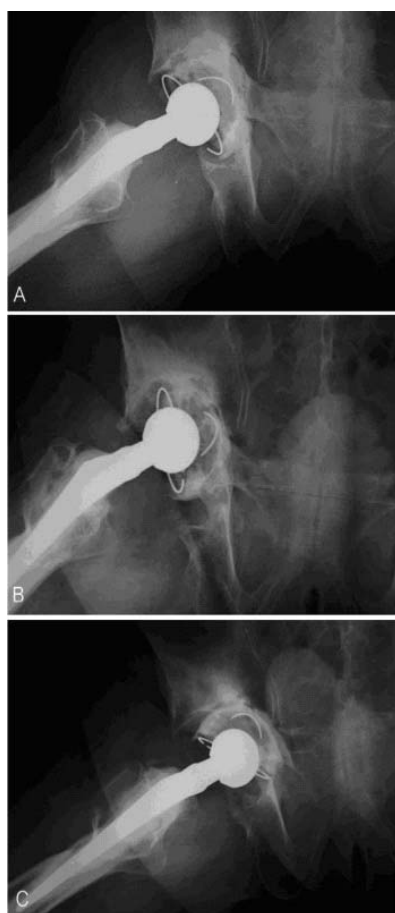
A: Radiograph at one year after index operation. There was a complete <1mm radiolucency line in all zones of right acetabulum. B: Radiograph at four years after index operation. There was migration and medial protrusion beyond the ilio-ischial line of the acetabular component. C: Radiograph at five years after index operation. There was a further medial protrusion and more horizontal orientation of acetabular component.
